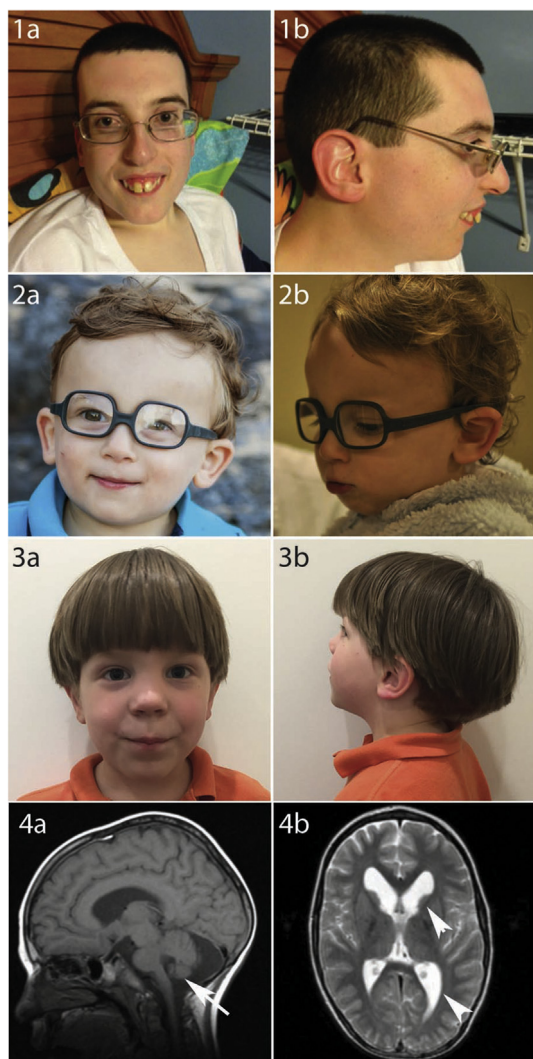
Photographs of study participants (1a–3b) and MRI findings (4a,b) in Patient 1.
